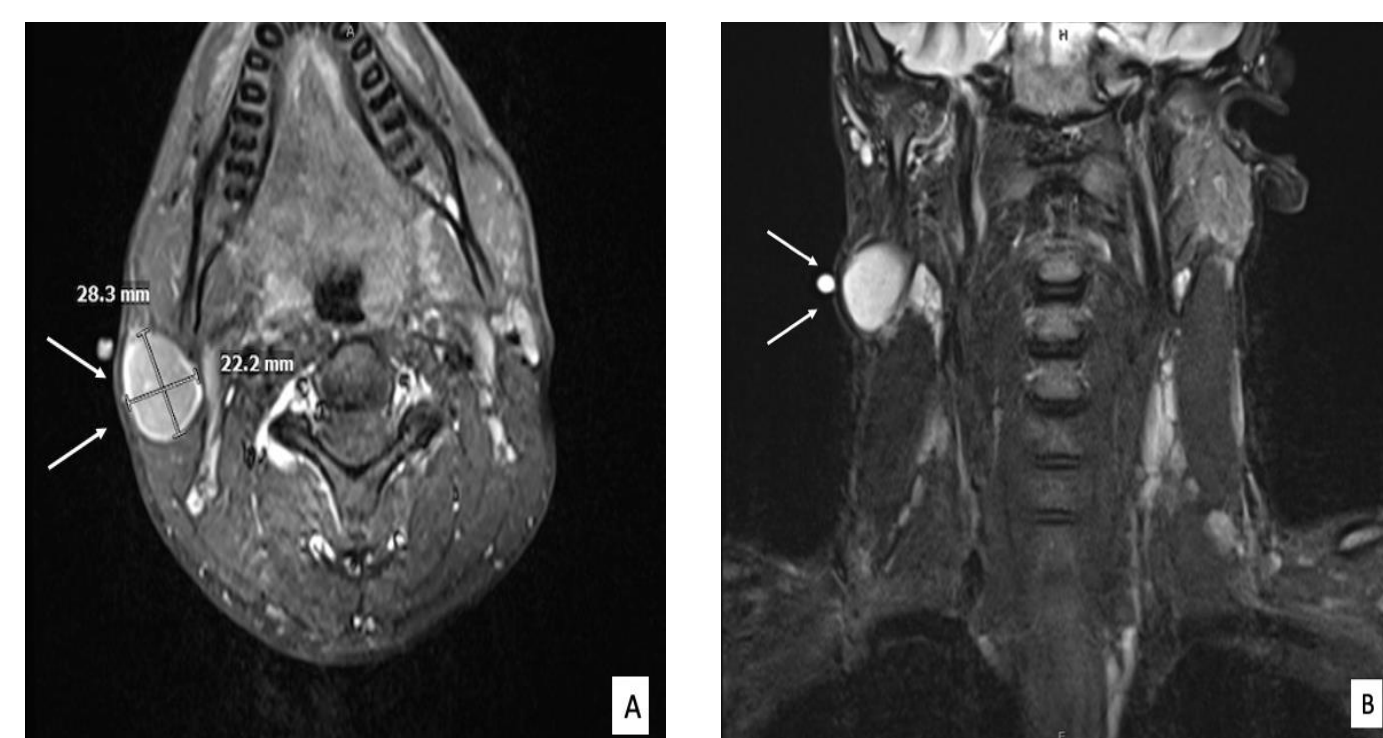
MRI with contrast axial (A) and coronal (B) images of right sided mass. This confirmed the presence of a mass, displaying characteristics suggestive of either lymphadenopathy or a branchial cleft cyst.
